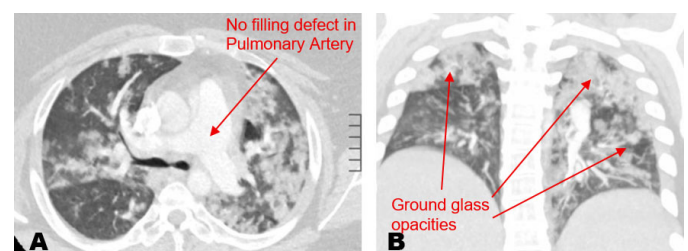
Initial computed tomography angiography (CTA) of the chest demonstrating multiple bilateral ground-glass opacities without evidence of pulmonary embolism on interpretation: (A) axial view and (B) coronal view.
